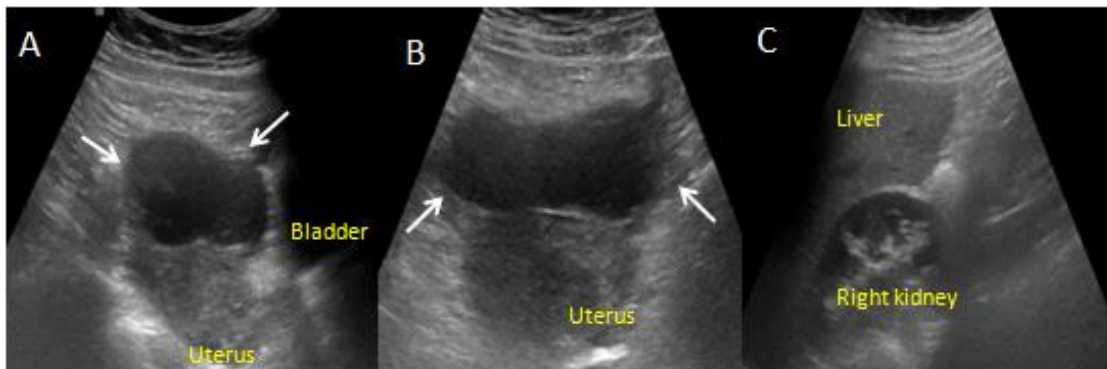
Repeat transabdominal ultrasound images in longitudinal (A, C) and transverse (B) plane show marked reduction in the size and echogenicity of left adnexal lesion (arrows) with no significant free fluid in pelvis and perihepatic region.
